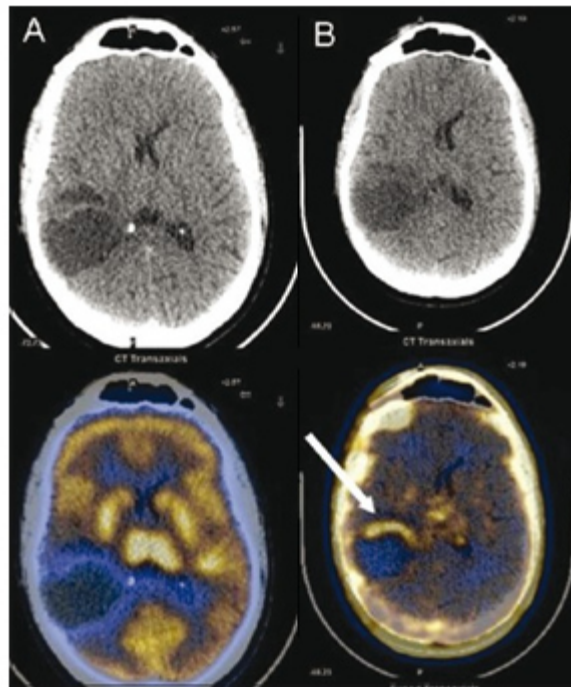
Patient suffering with a grade III glioma, postoperative examinations. (A) FDG PET/CT image showing no abnormal tracer uptake at the operative site. (B) FLT PET/CT image shows evidence of tumour recurrence anteriorly at the periphery of the lesion (arrow) (46).
